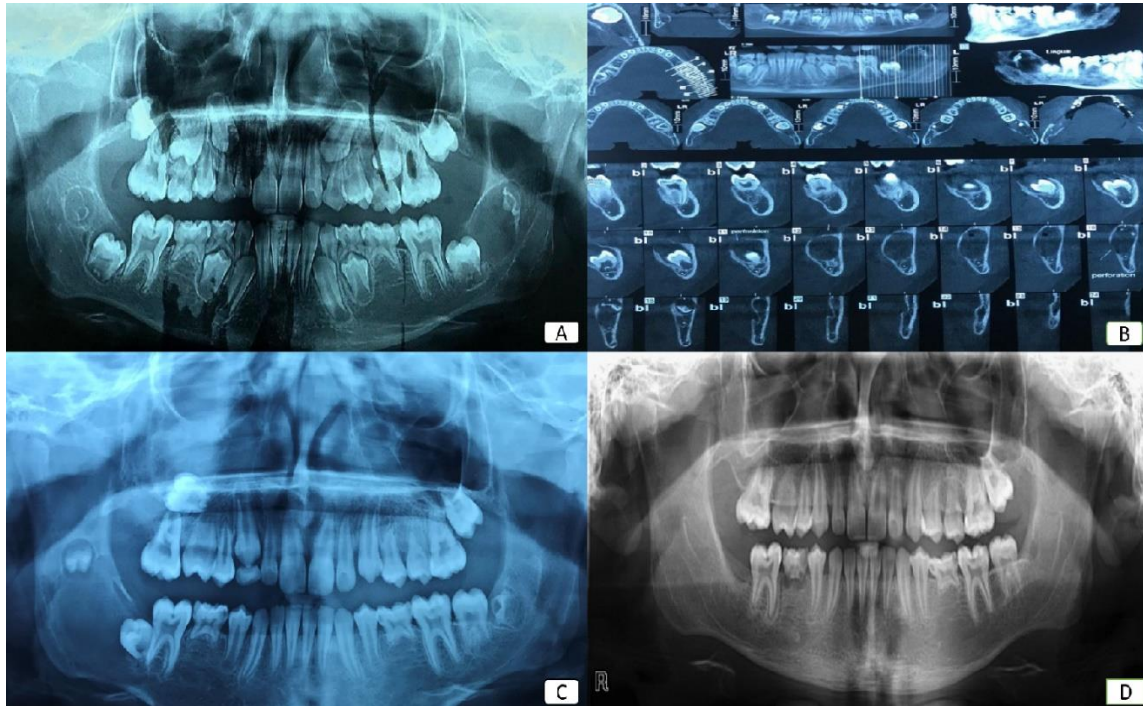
A) Radiolucent lesion on the left side of the mandible is pericoronal to the impacted third molar and extended from the distal of first molar to near the ascending ramus. B) Lesion with a cortical margin and perforation of the mandibular plate of the ramus and alveolar ridge. C) Radiolucencies with impacted and displaced right maxillary second molar and displaced bud of the right mandibular third molar and impacted right mandibular second molar. D) Follow up radiograph; note the radiolucent lesion in the distal region of the second molar
